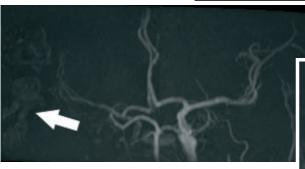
Embolized PICA aneurysm. In T1-weighted imaged (A) hyperintense ferromagnetic artefact (arrow) is showed. This artefact is visualized in conventional MRA too, both in single partition (B) and in MIP reconstruction (C); instead subtractive MRA is not disturbed (D: single partition, E: MIP reconstruction).
